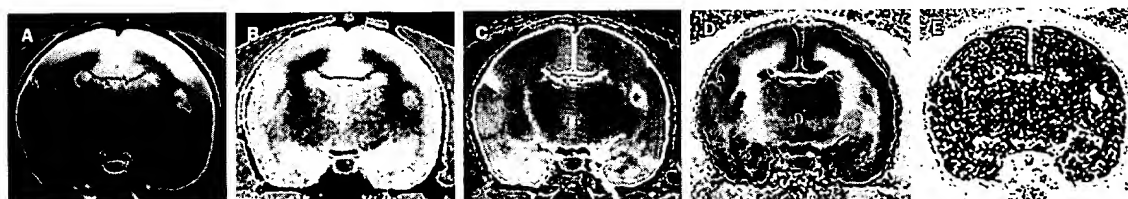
MRI of recombinant-human-MOG-induced EAE in marmosets. High contrast T2-weighted images (A) are used to visualise abnormalities in white matter. The specificity of MRI can be increased by using T1 (B) and T2 (C) relaxation-time images and magnetisation transfer (D) images. Images created by subtraction of images recorded before and after intravenous injection of gadolinium-DTPA 300 $\mu\text{m/kg}$ (E) visualise the permeability of the blood-brain barrier.
